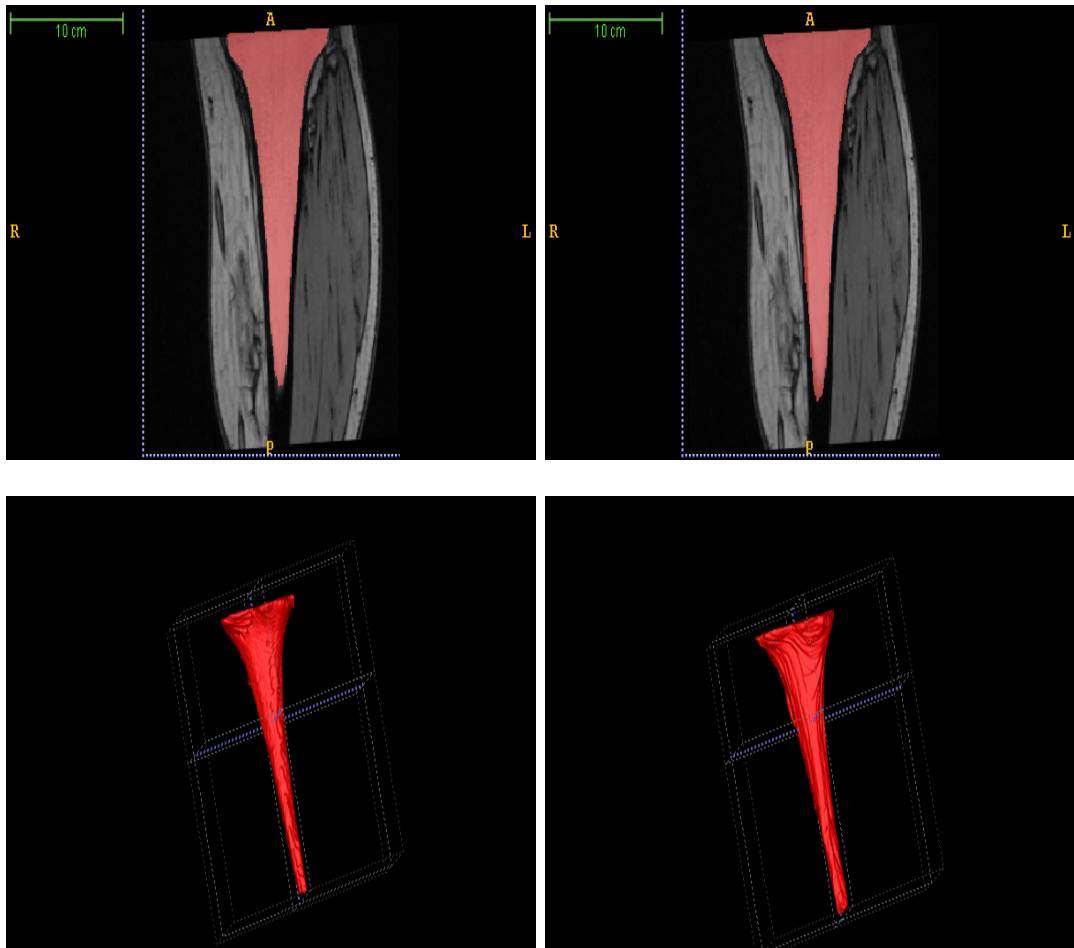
Segmentation of tibia (shown in red) on T1 weighted MRI are shown in 2D sagittal slices and 3D volume. Left column shows the result of our employed segmentation method, right column shows the result of manual segmentation for comparison. We can see that our segmentation method gives similar result to that of manual segmentation.
